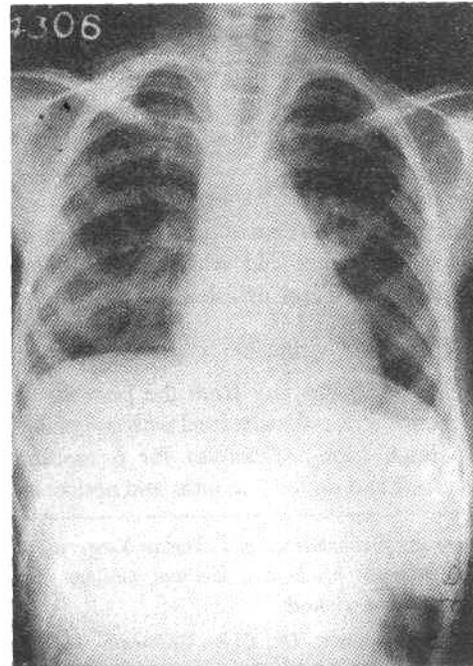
X-ray chest after surgery showing full expansion of the right lung.
